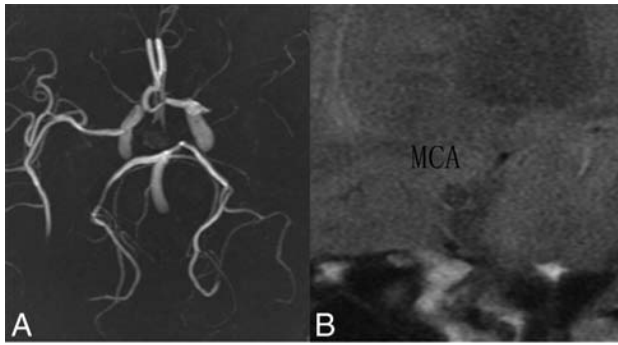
Representative MR angiography and high-resolution T2-weighted imaging findings. *A*, 3D time-of-flight MRA reveals an occlusive left middle cerebral artery. *B*, Plaque with heterogeneous signal intensity was present in the MCA lumen on HR-T2WI.
